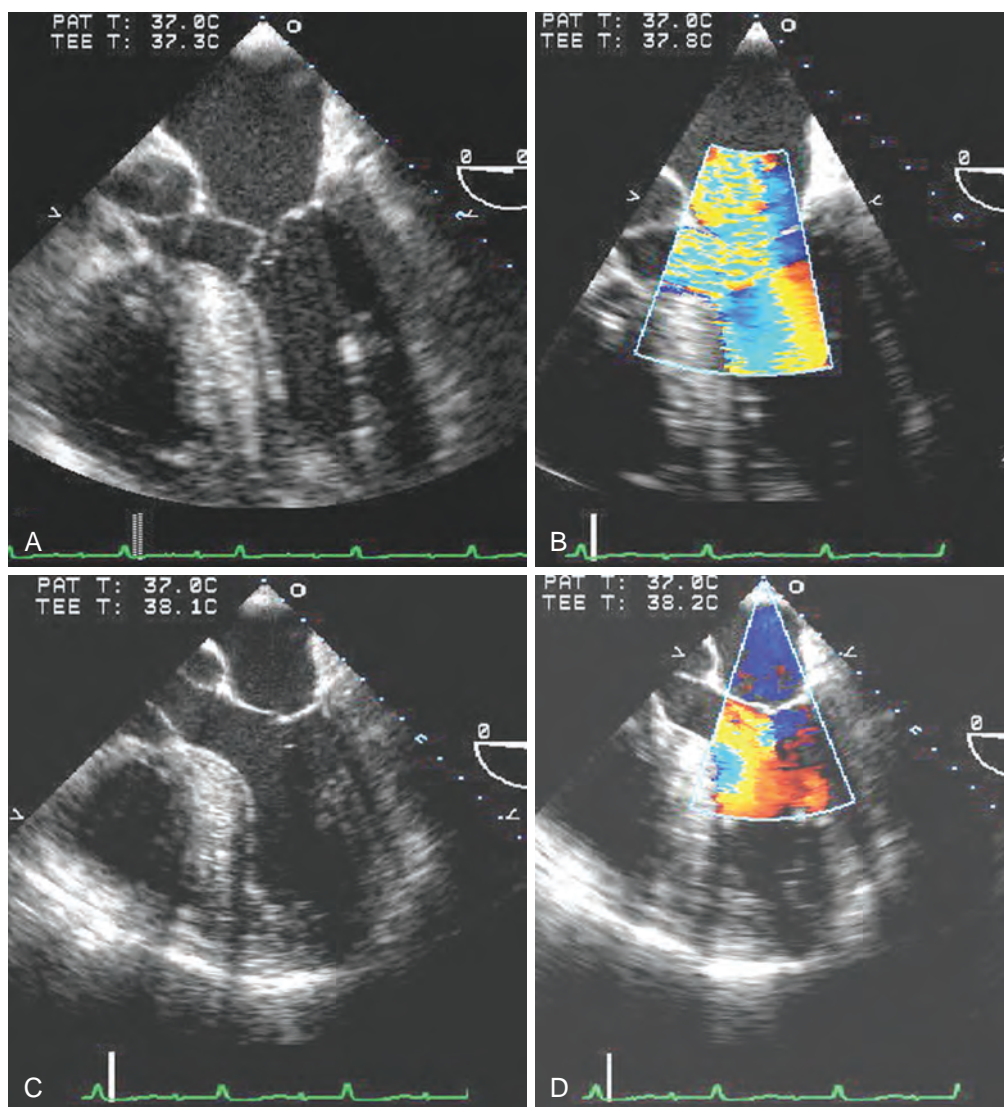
Acute intraoperative hemodynamic deterioration. A 65-year-old man with a medical history of hypertension, sleep apnea, and smoking was scheduled for resection of colon cancer. During the bowel resection, the patient had a profound episode of hypotension and new-onset hypoxia. Although the patient's hemodynamic condition initially improved after administration of phenylephrine and ephedrine, the patient became more hypotensive and hypoxic with evidence of pulmonary edema. Transesophageal echocardiography was requested and was performed on an emergency basis to diagnose the cause of cardiovascular collapse and to guide management. (A) The midesophageal four-chamber view showed a moderately hypertrophied left ventricle. Left ventricular (LV) systole was associated with displacement of the mitral leaflet and chordae tendineae down into the outflow tract. The resulting defect in leaflet coaptation of the mitral valve (MV) and the abnormal chordal position noted in (A) were associated with overwhelming mitral regurgitation (MR) and LV outflow tract obstruction. (B) Administration of inotropes (epinephrine and ephedrine) was discontinued; the management strategy was changed to volume resuscitation and pressor administration. (C) and (D) The hemodynamics normalized, and the examination was repeated 10 minutes later. Displacement of the mitral leaflet and chordae had resolved, together with the findings of MR and outflow tract obstruction. The patient was believed to have experienced a profound acute decline in systemic vascular resistance in response to the release of vasoactive substances during bowel manipulation. The initial exacerbation of the hemodynamics was created by the relative hypovolemia and the use of inotrope, thus leading to dynamic LV outflow tract obstruction. The concomitant episodes of hypoxia and pulmonary edema, which were attributed to the severe MR and increased left atrial pressures, resolved with the decrease in MR. The application of transesophageal echocardiography was critical in making the correct diagnosis, altering management strategies, and initiating the appropriate therapy.
